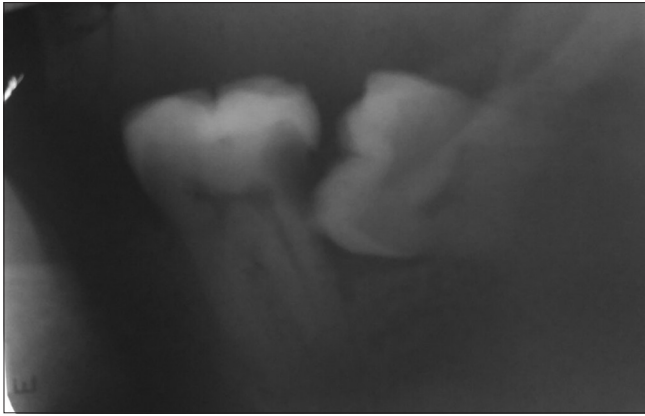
Intraoral periapical showing carious second molar with mesioangular third molar.
